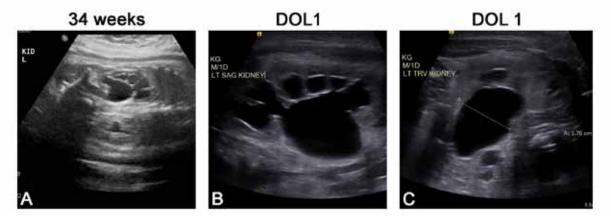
Prenatal and postnatal appearance of prenatally diagnosed ureteropelvic junction obstruction. *A*, fetal kidney at 34 weeks of gestation with dilated renal pelvis and peripheral calyceal dilation. *B*, postnatal ultrasound with large dilated pelvis and peripheral calyces without ipsilateral ureteral dilation. *C*, anterior posterior renal pelvis diameter.
